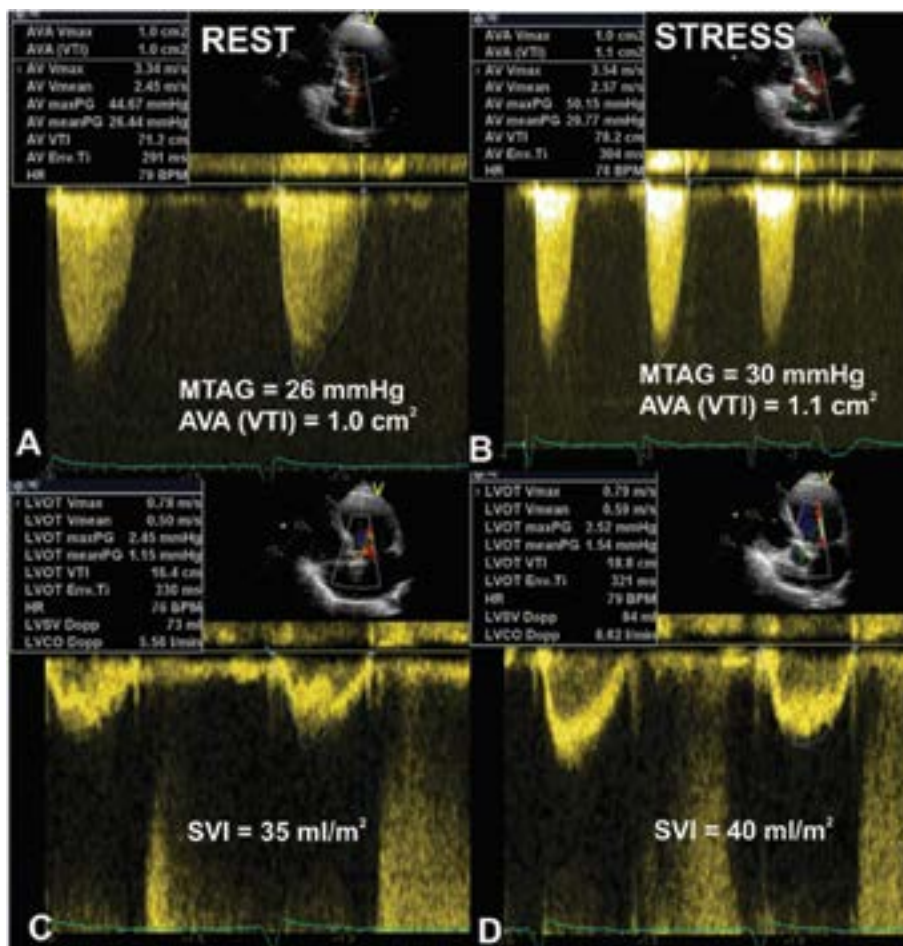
Doppler findings obtained while performing DSE in symptomatic male patient with LFLG AS. At rest (left panels) there is low-flow situation with SVI of about 35 mL/m² (C) and low gradient with an MTAG of 26 mm Hg (A). At peak low dose DSE (left panels) the absence of LV flow reserve (15% increase in SV) (D) and indeterminate severity of AS (MTAG = 30 mm Hg, AVA = 1.1 cm²) (B) was observed. After the assessment of calcium score by CT (1000 Agatston units) it was decided to treat patient conservatively. Abbreviations are the same as in Figure 1
